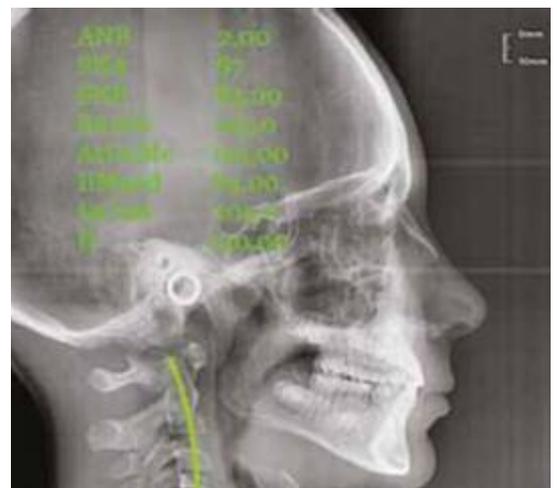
radiography at 2 years: postural recovery with restoration of the normal cervical curve
